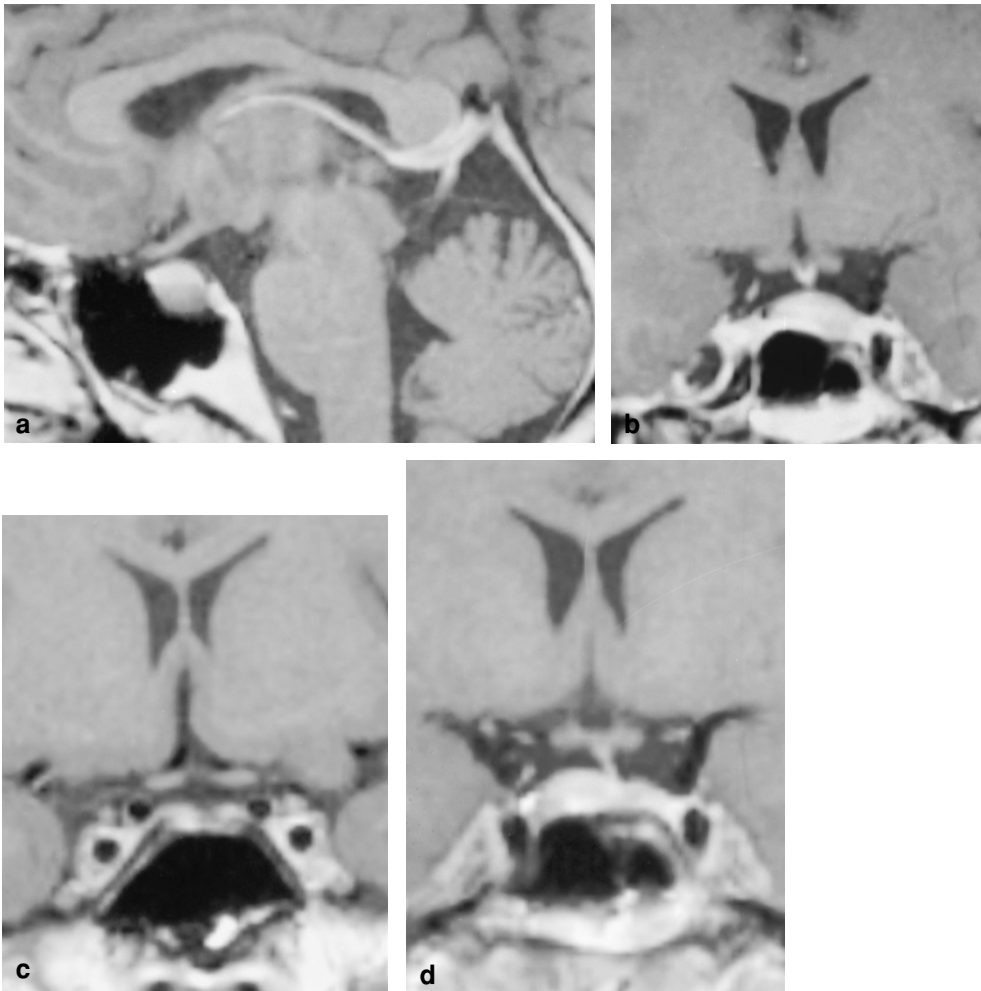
The T1-weighted MR images in patient no. 13 are shown: pre-operatively a pituitary adenoma is present in the left lobe as shown in the sagittal scan (a) and in the coronal one (b); 12 months after transsphenoidal surgery the pituitary lesion has disappeared (c); 26 months after pituitary surgery a positive image of pituitary adenoma is present in the right lobe (d)
